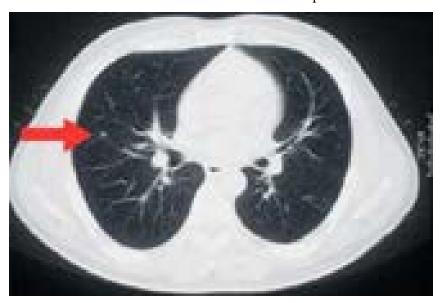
2D CT scan slice containing a small (5mm) early stage lung cancer nodule.
